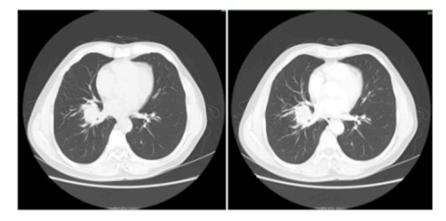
A computed tomography (CT) scan of the chest reveals several enlarged lymph nodes in the mediastinum and right lung, as well as a  $4.3 \times 3.5$  cm2 soft tissue density shadow in the lower lobe parenchyma of the right lung field. There was a 19 mm circular lesion in the hilum and an oval lump measuring 3 mm by 25 mm in the lateral part of the left adrenal gland.
